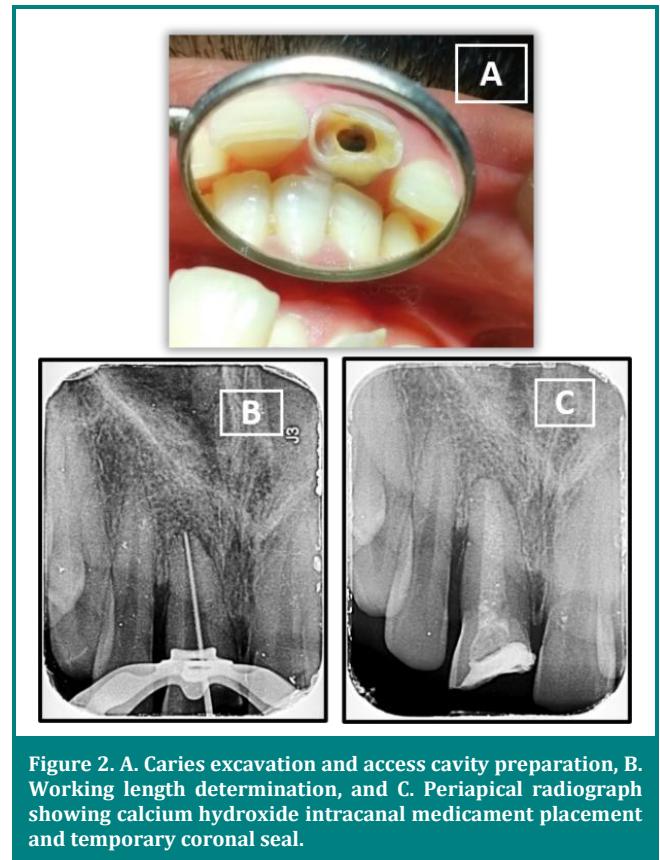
A. Caries excavation and access cavity preparation, B. Working length determination, and C. Periapical radiograph showing calcium hydroxide intracanal medicament placement and temporary coronal seal.
